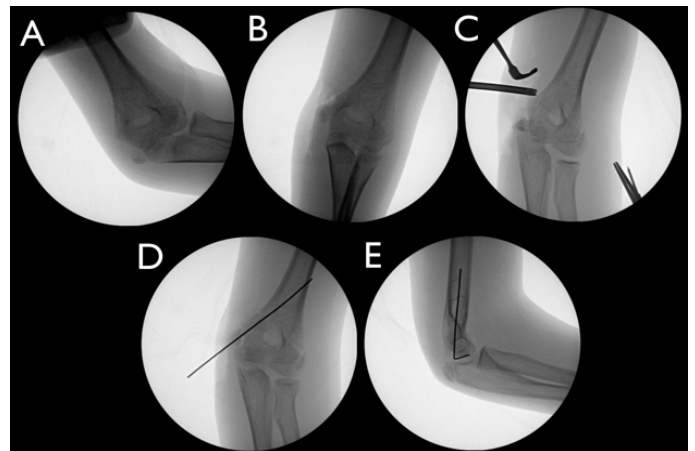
Intra-operative radiographs. Valgus instability is confirmed under fluoroscopic guidance (A). Dissection performed down to fracture site and medial epicondyle is reduced (B). Flexor-pronator flexor wad aponeurosis and UCL are whipstitched, fragment is reduced, and fracture is stabilized with K-wire and suture anchor (C, D, E).
